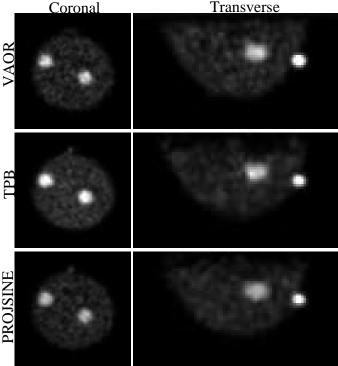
Reconstructed, SPECT-based attenuation corrected SPECT images of the breast with methanol (right in coronal image) and water (left in coronal image) lesions collected with trajectories as indicated. The dot outside the breast seen in the transverse images is one of the fiducial markers.
